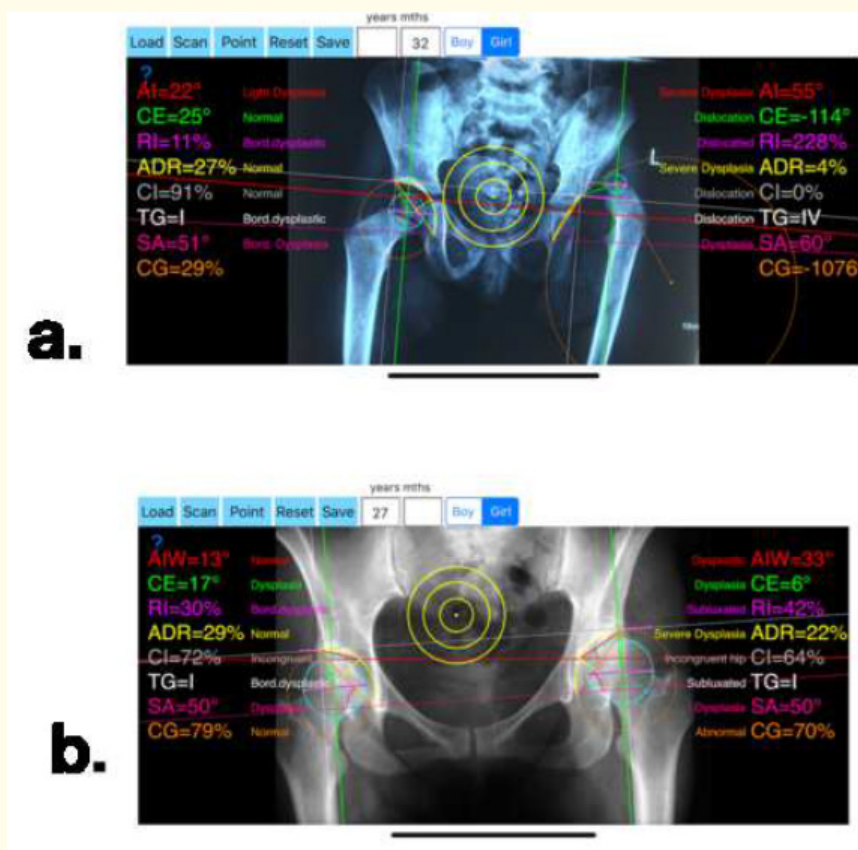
Radiographic Indexes calculated using the HipDysplasiaApp.
